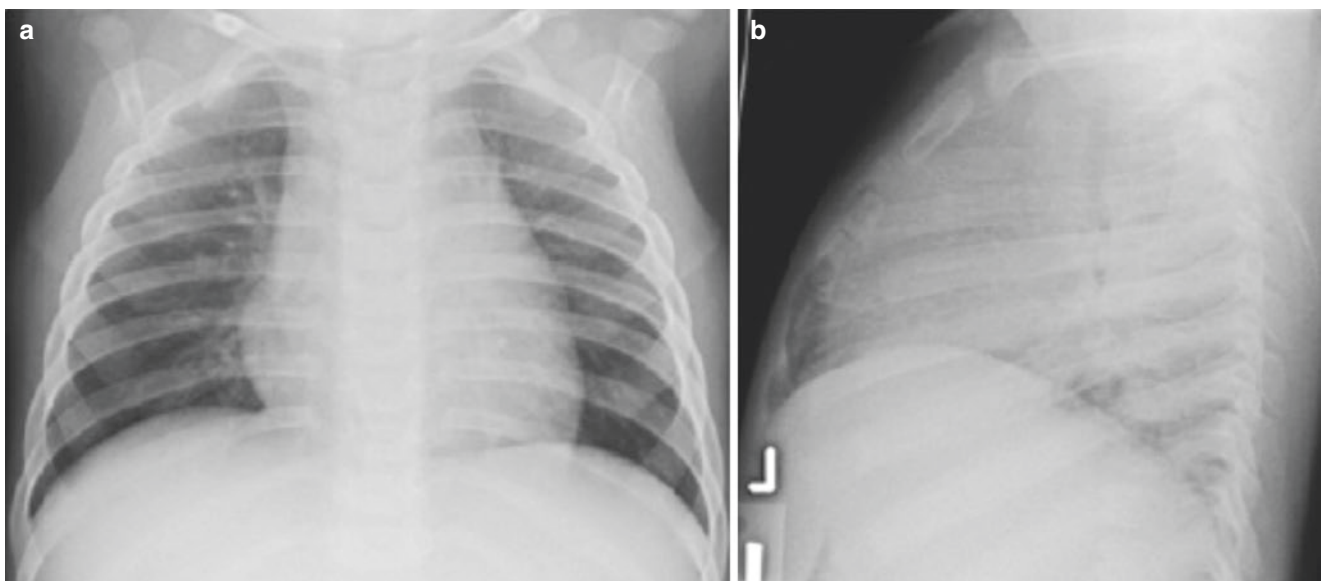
Normal (a) AP and (b) lateral radiographs of an infant girl demonstrate that the anterior ribs curve downward relative to the posterior ribs and that the hemidiaphragms are curved on both the AP and lateral views
